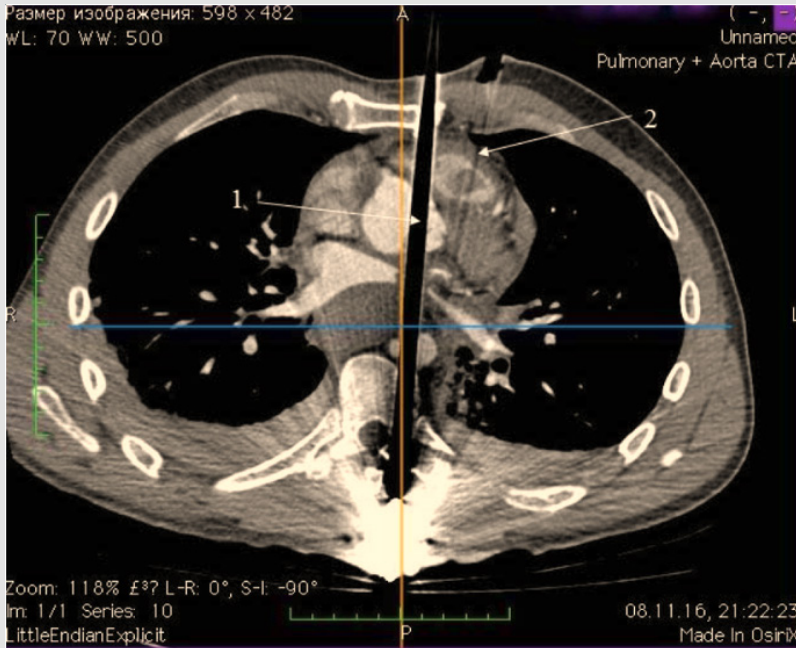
Chest CT, foreign bodies (booms) are marked.
